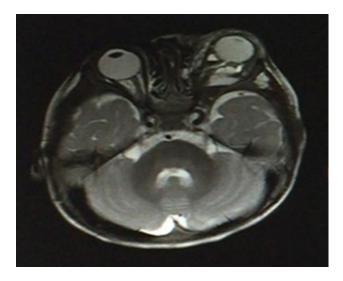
Showing the tumour in the left orbit and proptosis of left globe on T2 MRI
